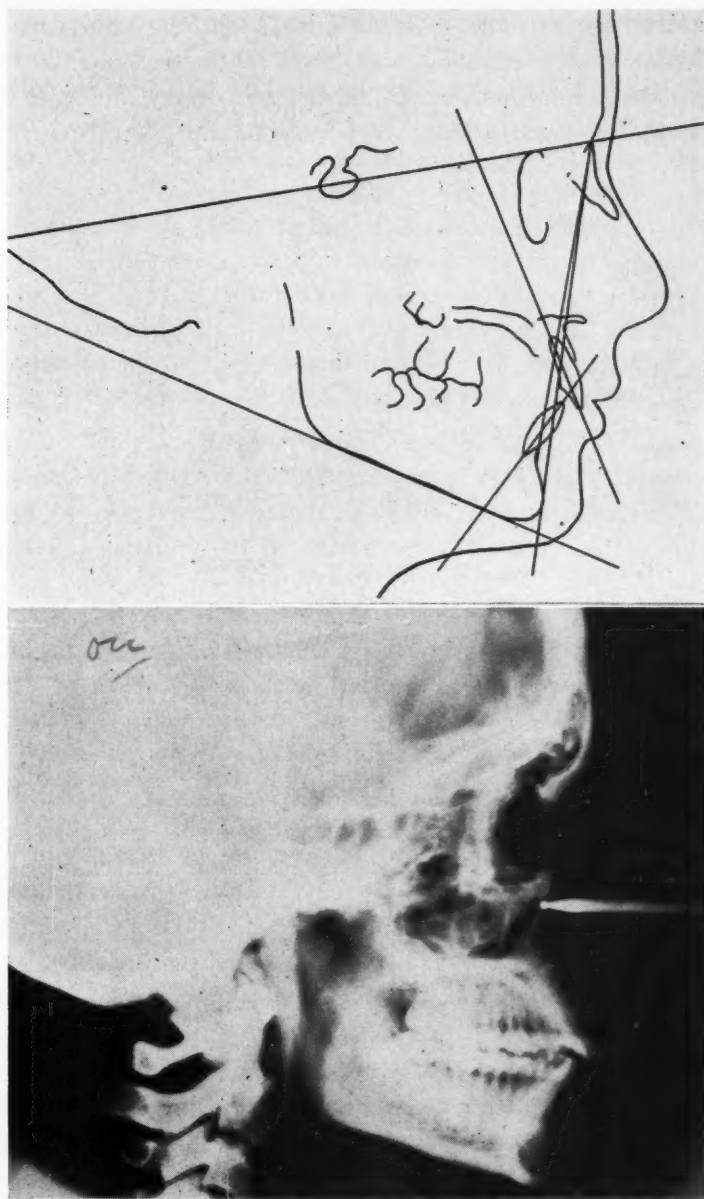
Patient J. H. Cephalometric radiograph and tracing in acquired terminal occlusion.
